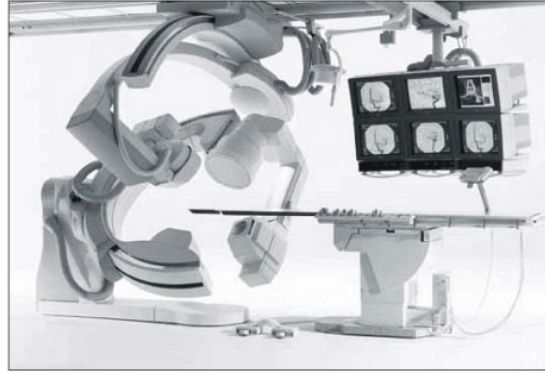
A bi-planar fluoroscopy C-arm machine. Such imaging machines have two image sensor and ray sources which capture two images of the subject with perpendicular focal axes. The use of bi-planar C-arm machines is advantageous over the single-plane alternatives due to the fact the the out-of-plane translation of each image series is in-plane for the other. However, such radiography machines are expensive and the extra imaging arm confines the subjects natural range of motion.
